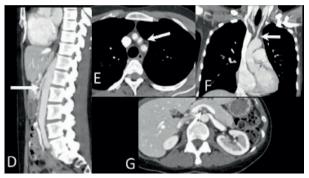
thoracic-abdominal computed tomography shows mural thickening (D) the mesenteric superior artery, (F) brachiocephalic trunk, and (G) right renal artery.
